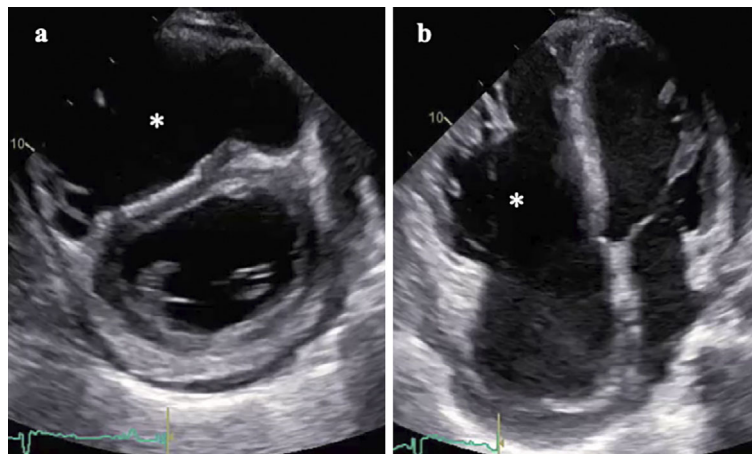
Echocardiography. Parasternal short axis (a) and apical four-chamber images (b) exhibiting right ventricular dilatation and dysfunction (asterisk) with flattened ventricular septum. Severe tricuspid regurgitation and left ventricular dilatation/dysfunction were also observed.
